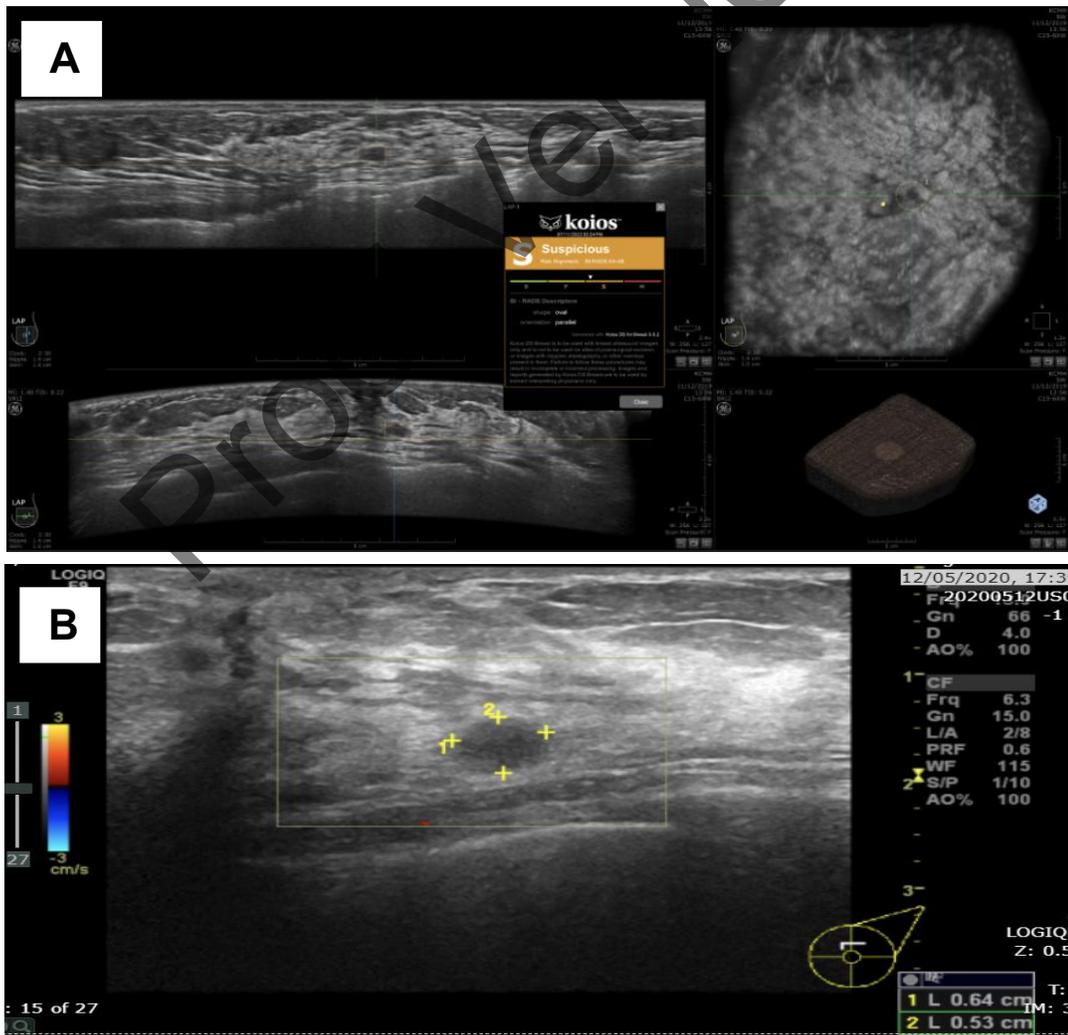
A 60-year-old female with invasive ductal carcinoma. She had a history of contralateral breast cancer. ABUS (A) demonstrates a circumscribed hypoechoic mass in the lower outer quadrant of left breast; BI-RADS 3. However, the AI decision support characterized this mass as suspicious. Subsequent 6-month follow-up with HHUS (B); the mass developed partial indistinct border, BI-RADS 4a. ABUS, automated breast ultrasound; AI, artificial intelligence; BI-RADS, breast imaging-reporting and data system.
